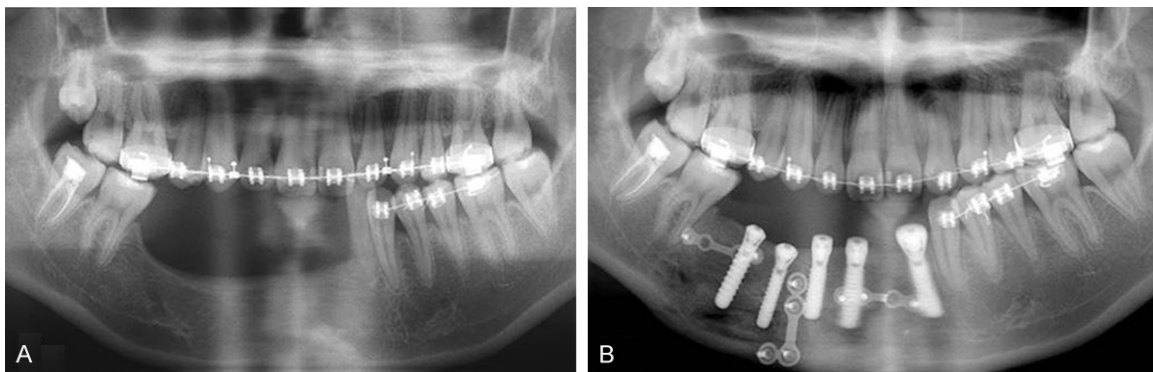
A. Panoramic radiographs revealed the height of the alveolar bone at the edentulous area was 5 mm lower than adjacent alveolar bone. B. Panoramic radiographs revealed good osseointegration between implants and bone before two stage operation.
